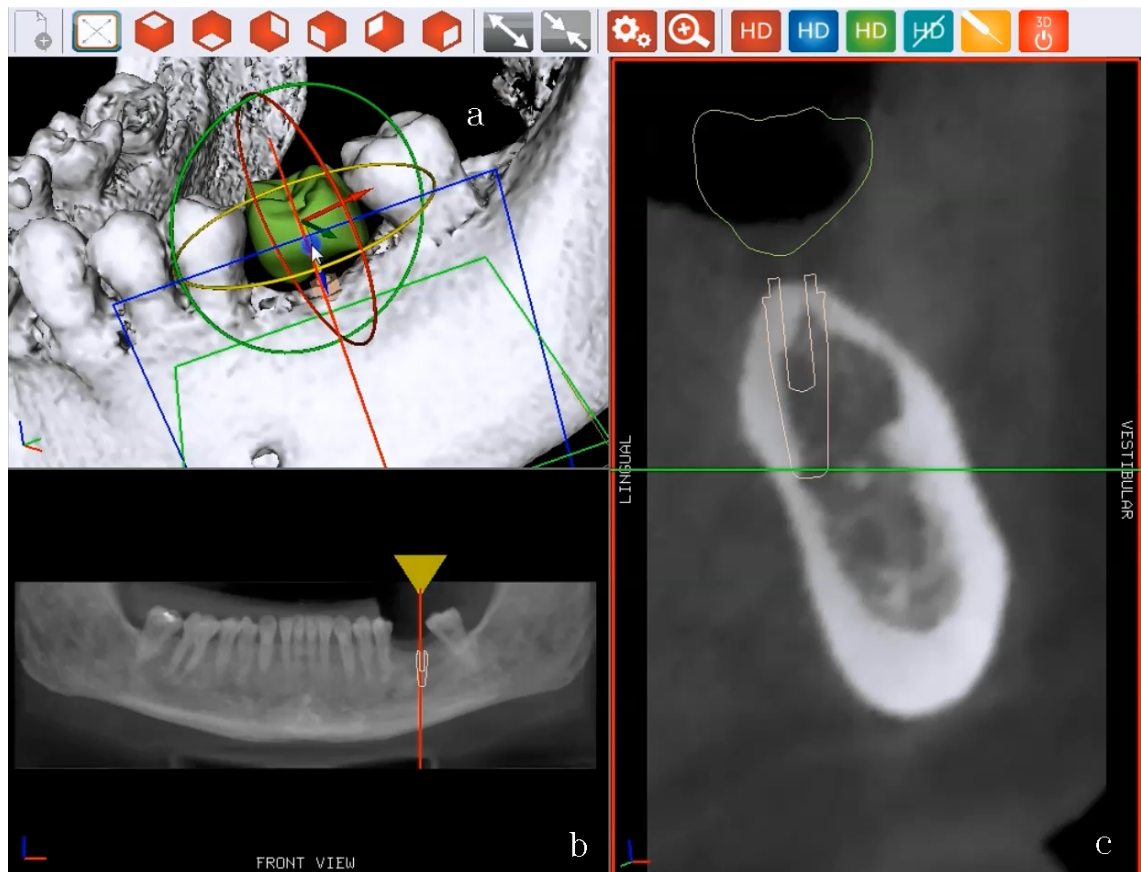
Virtual tooth function: after being selected from a library of prostheses, the virtual tooth is displayed in axis with the planned implant with a default offset in the vestibule-lingual view (c). The user can modify the position of the implant by dragging transformation handles shown in the three-dimensional view (a). The contour of the virtual tooth can also be explored by dragging the yellow handle in the orthopantomographic view (b).
